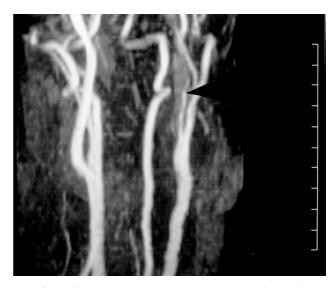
MRI demonstrating occlusion of the left internal carotid artery (arrow)
